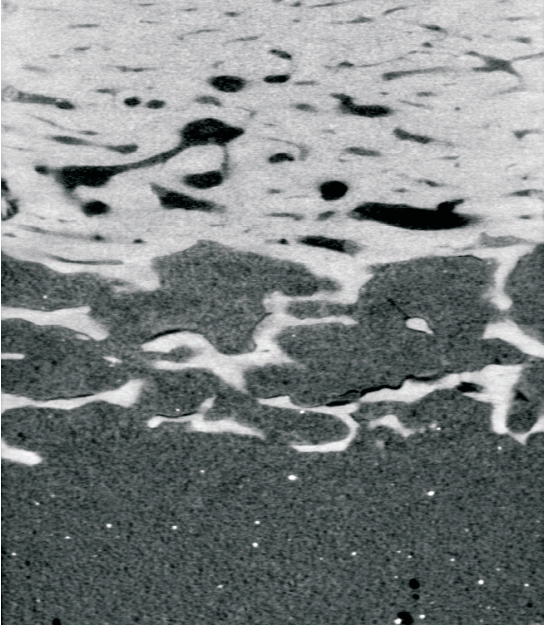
CT-image of the cement-bone interface
